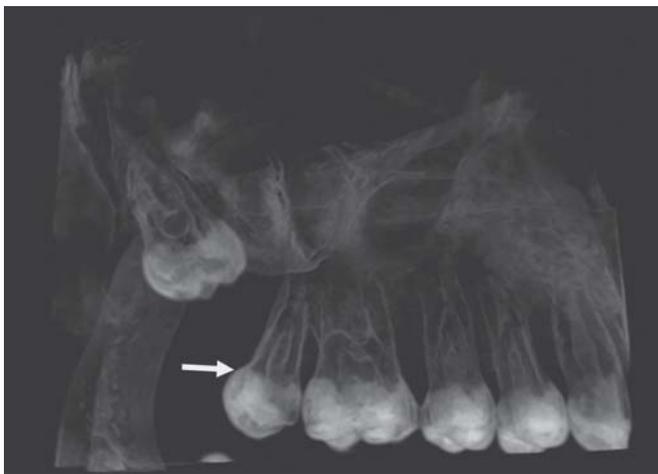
CBCT image (3D buccal view—right side)
